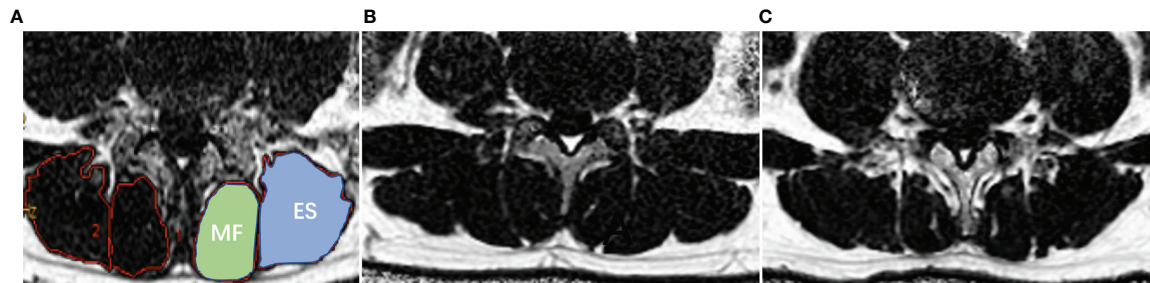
Demonstration of paraspinal muscle segmentation and MRI PDFF of lumbar paraspinal muscle in patients with DLBP. (A) Processed PDFF maps of paraspinal muscles; manual segmentation of paraspinal muscles. MF: multifidus, and ES: erector spinae. (B) Healthy Volunteer, male, 32 years old, PDFF_{left MF} = 7.3%, PDFF_{right MF} = 7.8%, PDFF_{left ES} = 8.5%, PDFF_{right ES} = 8.7%. (C) Patient with DLBP, male, 28 years old, DLBP for 6 years, PDFF_{left MF} = 18.4%, PDFF_{right MF} = 19.7%, PDFF_{left ES} = 12.0%, PDFF_{right ES} = 13.9%.
